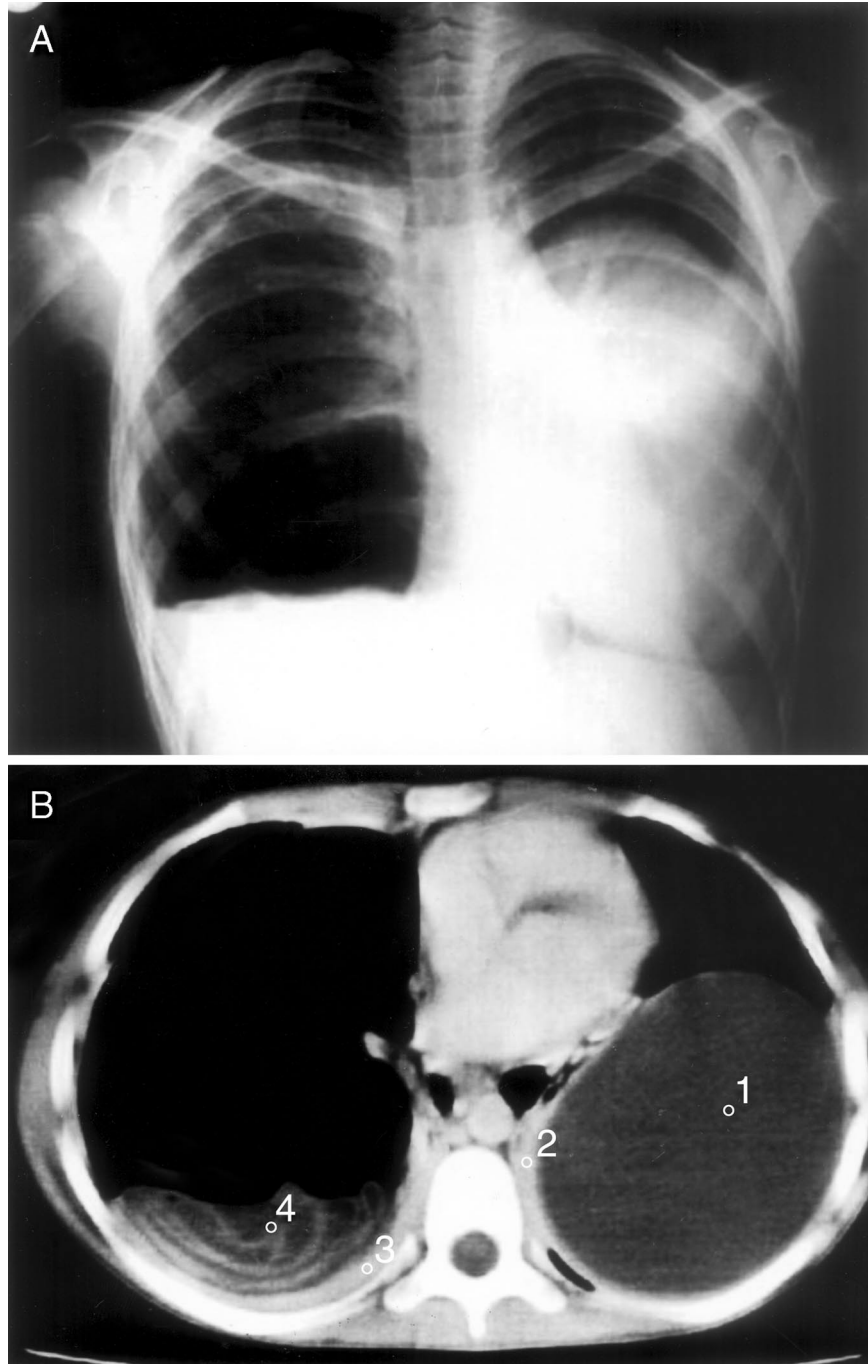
Ruptured right and intact left lung hydatid cysts in the chest radiograph (A) and thorax CT scan (B)
